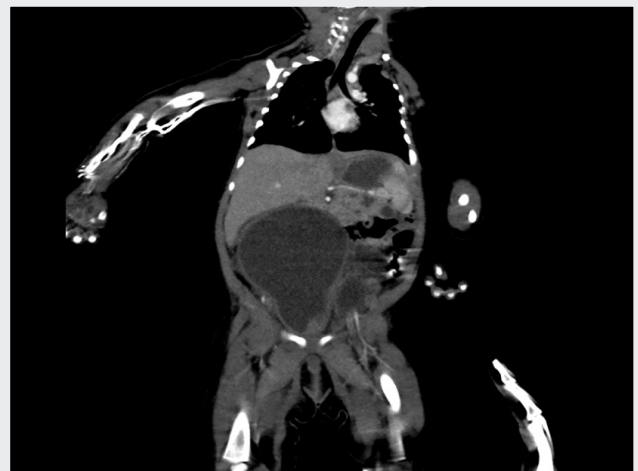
Abdominal CT showing cystic structure with fluid in the abdomen
